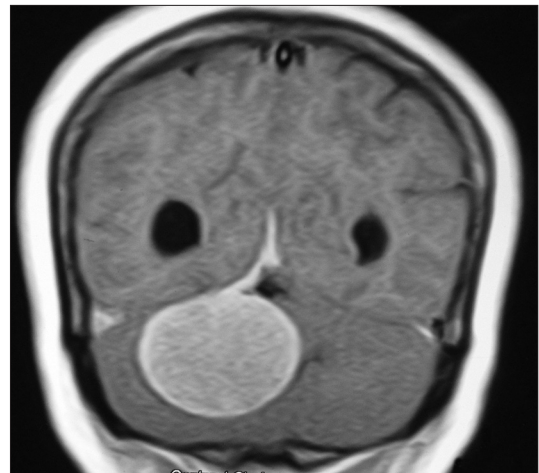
Preoperative MRI coronal cut T1-weighted contrast image shows tentorial dural tail sign
